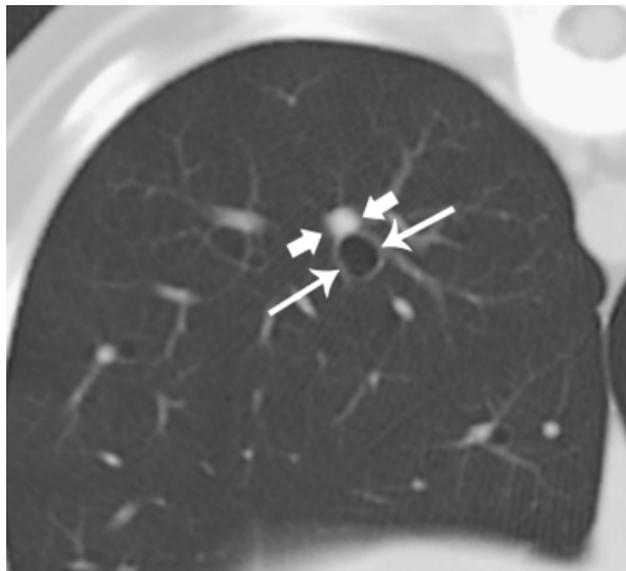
Computed tomography image of the thorax at the level of the 11th rib. The internal diameter of a representative bronchial lumen and the diameter of the corresponding pulmonary artery in cross-section were measured with electronic calipers. In this image, the measured bronchus in the right caudal lung lobe is designated by large, thin arrows while the corresponding pulmonary artery is designated by short, thick arrows. The bronchoarterial ratio is 1.29. For the images in this paper, the patient's left is to the right of the image.
